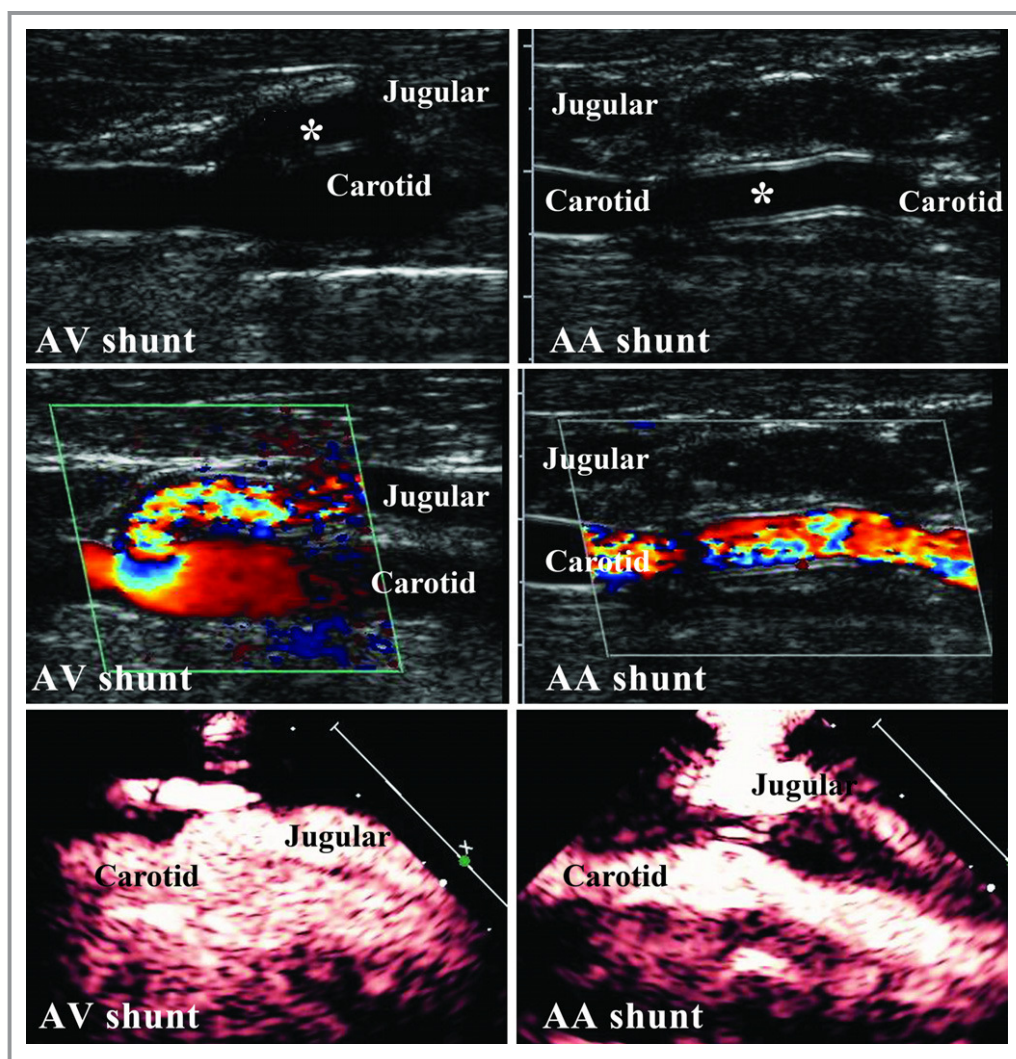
Transcutaneous echocardiographic images of extracardiac shunts. The arteriovenous (left panels) and arterio-arterial (right panels) shunts are demonstrated (asterisks) on 2-dimensional and color Doppler imaging, and during thromboprophylactic application of microbubbles and high mechanical index pulse sequences to insonify each shunt. AA indicates arterio-arterial; AV, arteriovenous.
